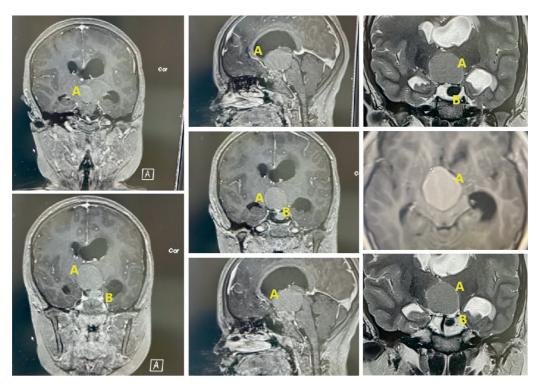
Preoperative contrast enhanced magnetic resonance images showing sellar–suprasellar lesion (A) extending into posterior fossa (B) suggestive of craniopharyngioma.
